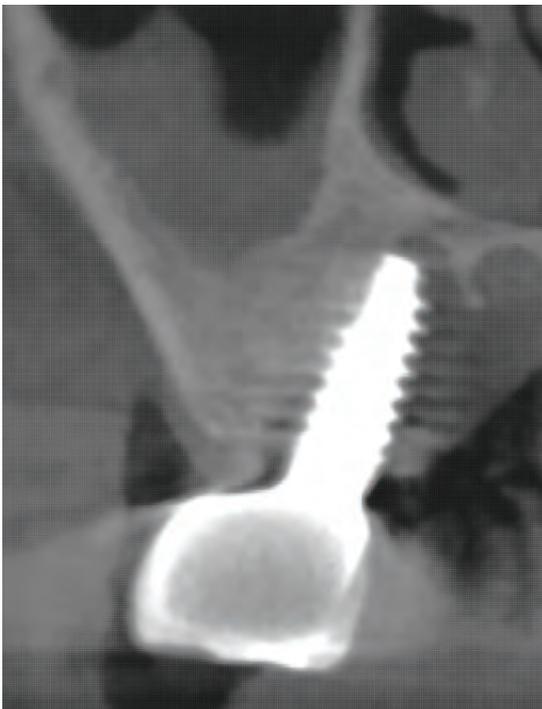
Implant UR7 seen in a cross section on CBCT showing that implant has missed the alveolar ridge due to severely restricted mouth opening and surgeon drilling at an angle from buccal. The implant tip is in contact with the neurovascular greater palatine bundle
